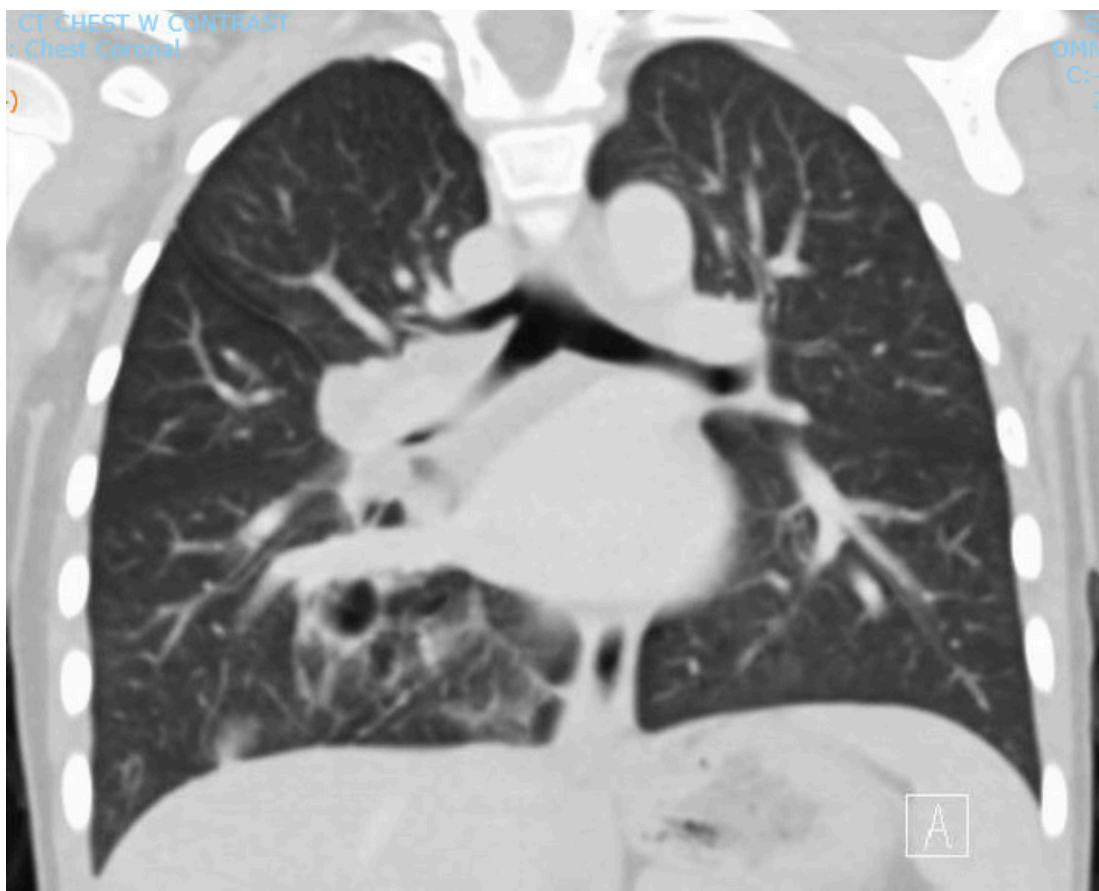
Preoperative CT Chest with previously undiagnosed tracheal bronchus. The official radiology read had no comment regarding any central airway abnormality.
